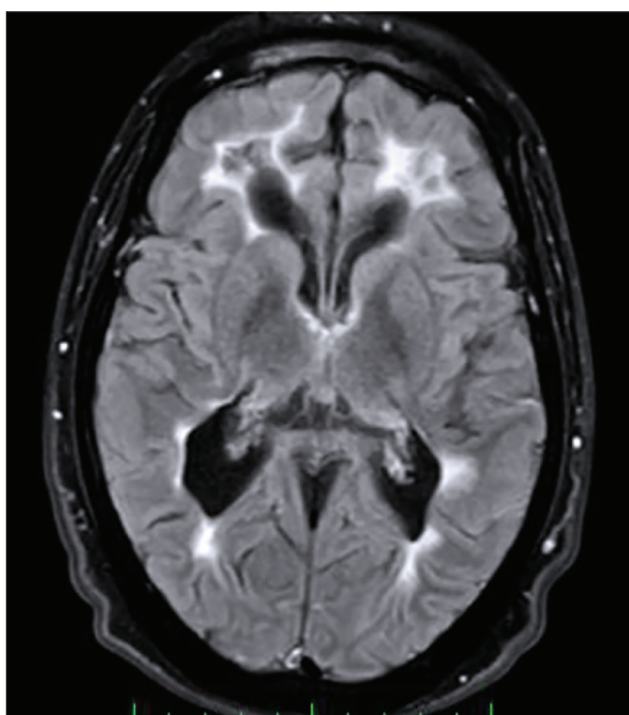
MRI FLAIR sequence revealed diffuse white matter hyperintensity and interspersed areas of low signal intensities findings in classic vanishing white matter (VWM) disease.
